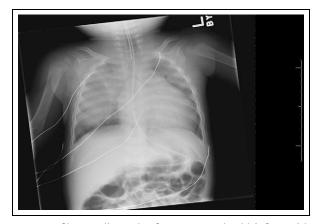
Chest radiograph of an 18-month-old infant with SS and severe ACS with diffuse bilateral infiltrates.
